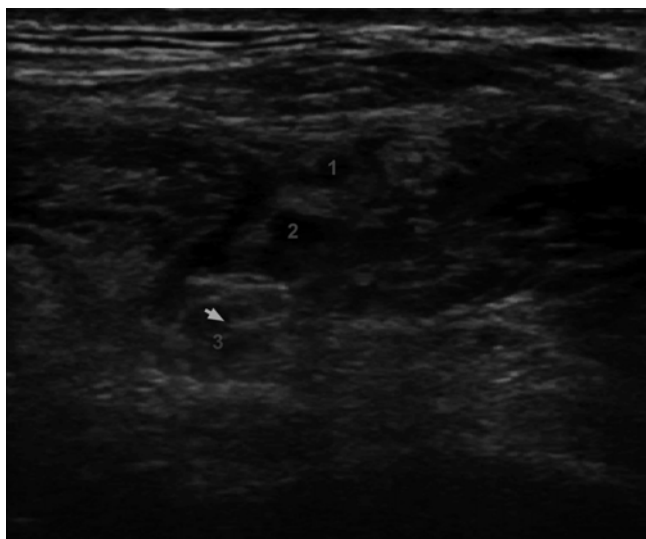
Ultrasonographic image of the brachial plexus during interscalene blockade. Shown are the superior (1), middle (2), and inferior (3) cords of the brachial plexus. The off-line review of the image demonstrated needle insertion in the inferior cord of the brachial plexus (*arrowhead*)
